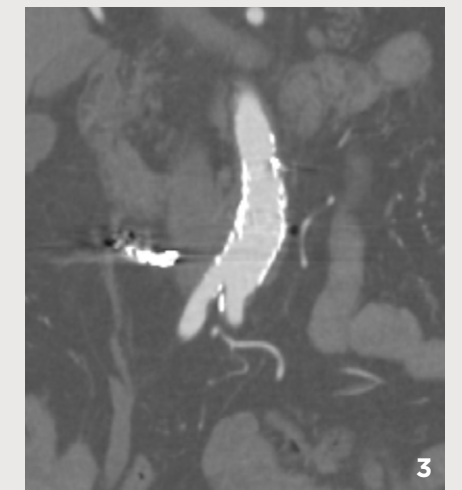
1 month post-operative CT scan demonstrates excellent endograft placement with complete exclusion of the aneurysm.
